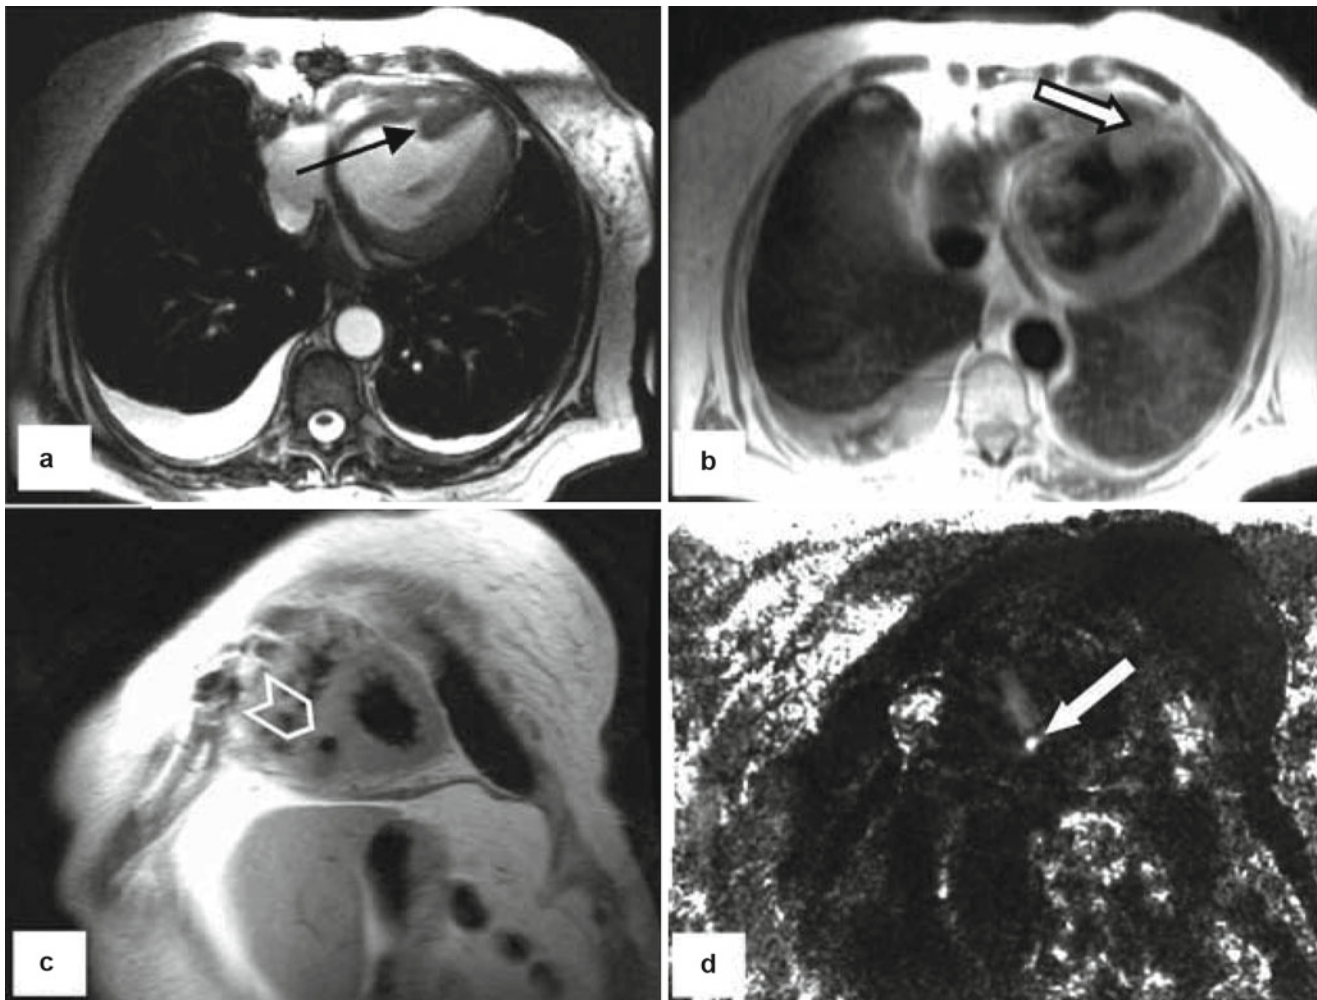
A 54-year-old female with progressive dyspnea 6 months following an anterior septal MI. A murmur was heard prompting an MRI evaluation. (a) A septal defect in the interventricular myocardium is seen (arrow). (b) The high-velocity flow between the LV and RV was diagnostic of a post-infarct VSD (arrow). (c) Selective breath-hold
